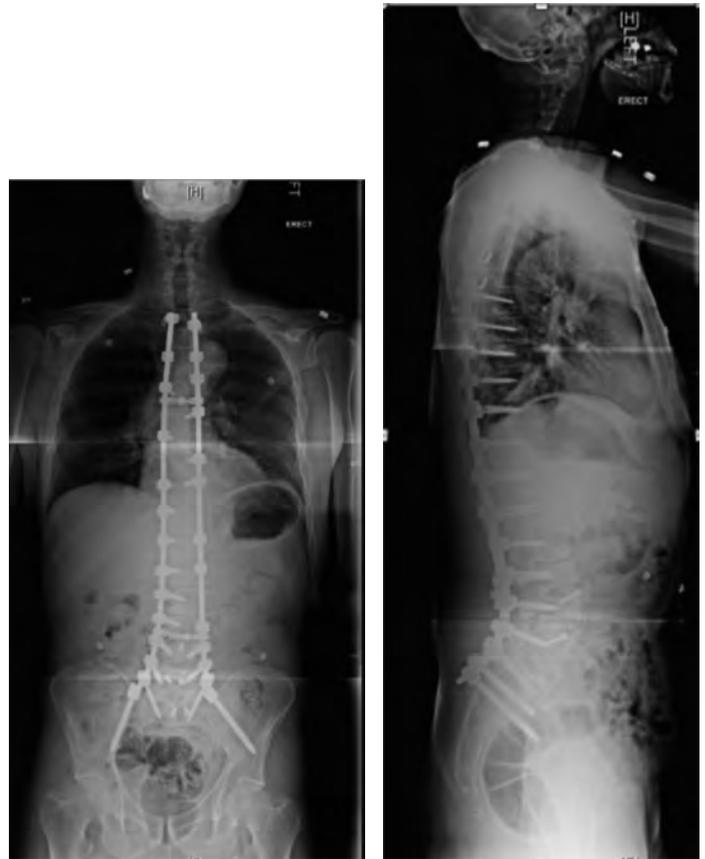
Post operative radiographs. Note improved sagittal balance.
